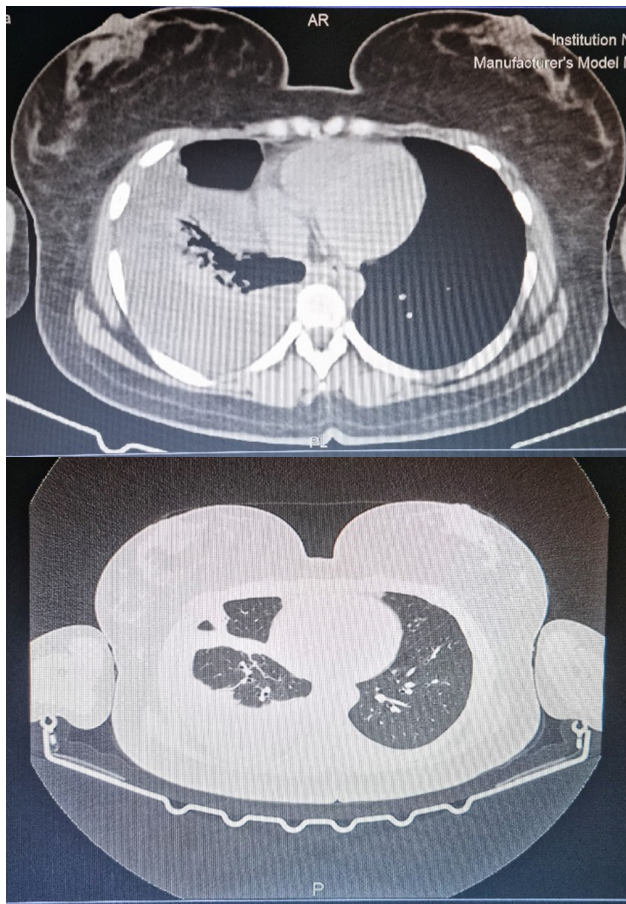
CT scan of chest showing right lung lower lobe consolidation and pleural effusion.
